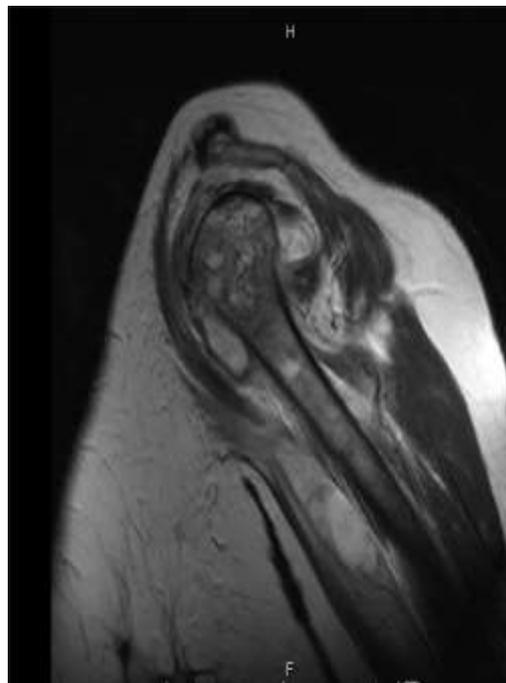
MRI scan of the shoulder showing AVN, bone marrow edema, fusiform fluid collection, effusion, cysts.
